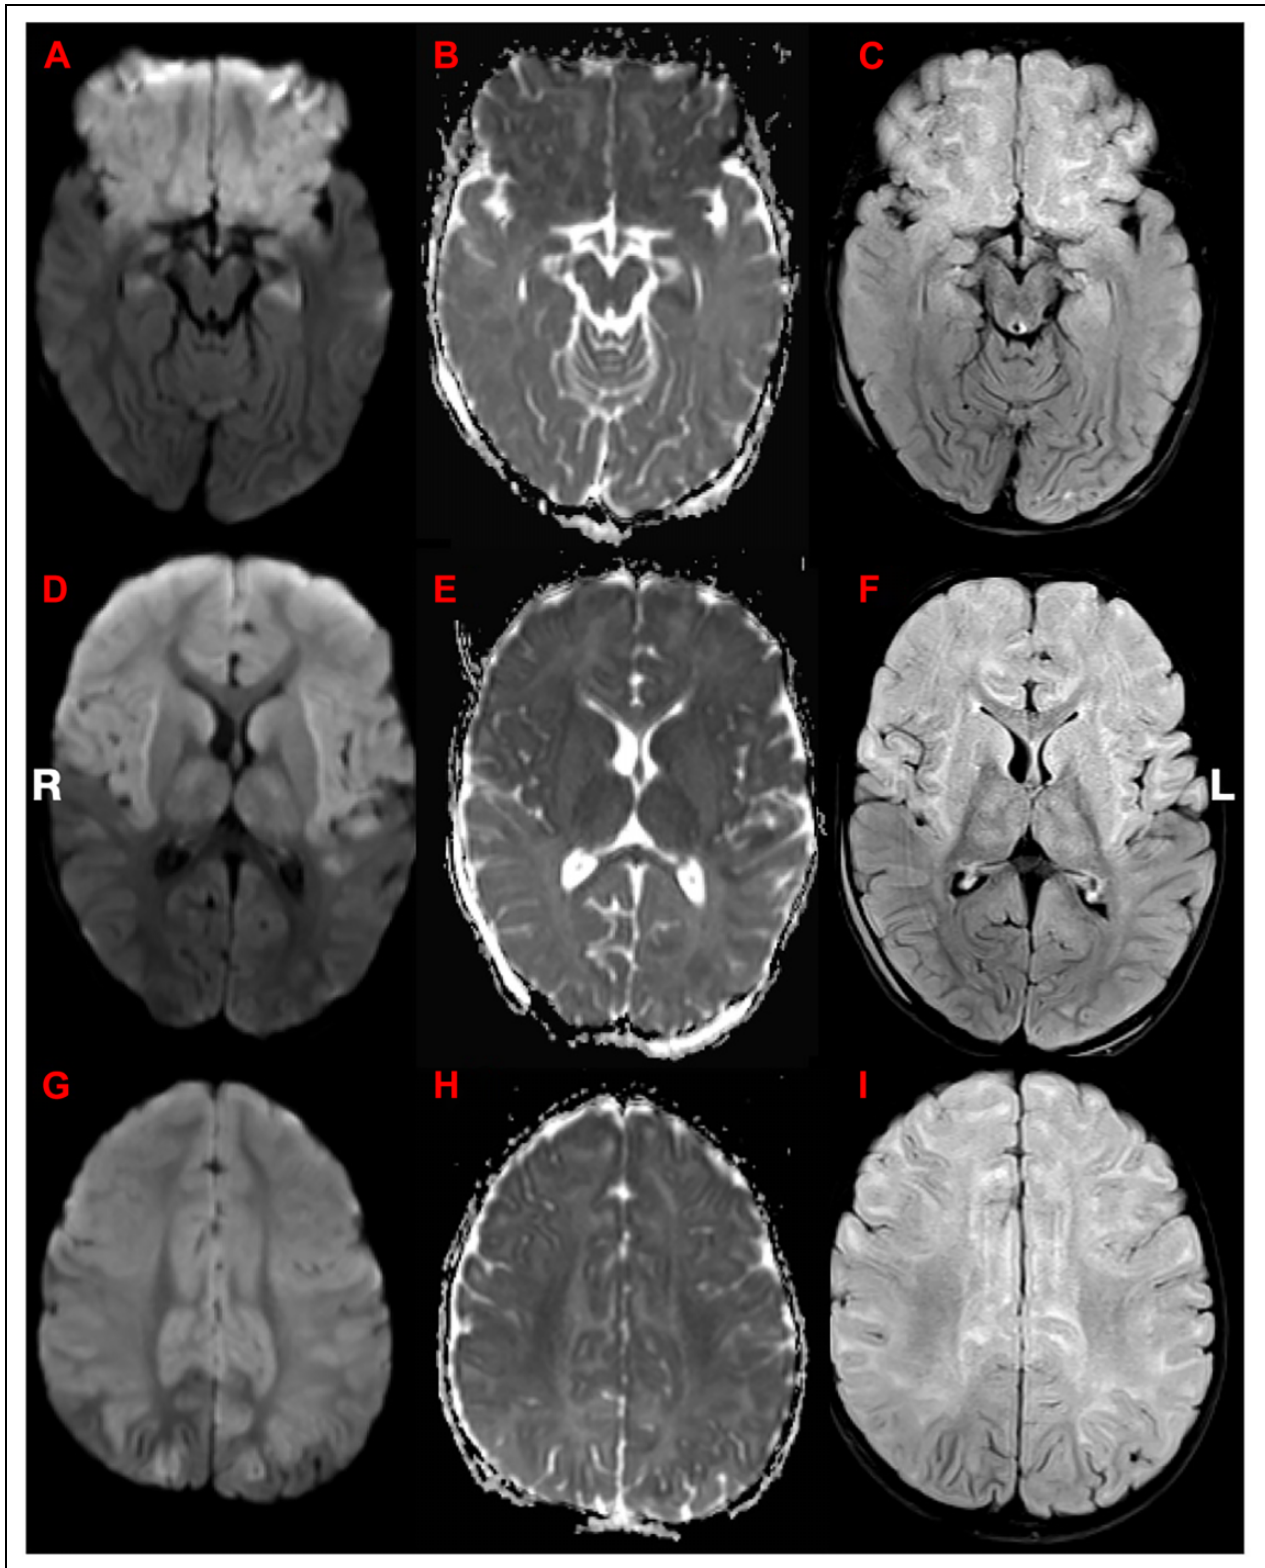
MRI brain with and without contrast. DWI sequence on day 10 shows symmetric restricted diffusion throughout both gray and white matter, specifically the bilateral frontal and medial temporal lobes, bilateral cingulate gyri, superior parietal lobes, basal ganglia, thalami, and internal capsules (A, D, G). Areas of restricted diffusion has associated ADC correlate (B, E, H) as well corresponding T2 FLAIR hyperintensities (C, F, I). There was no enhancement or SWI dropout visualized.
